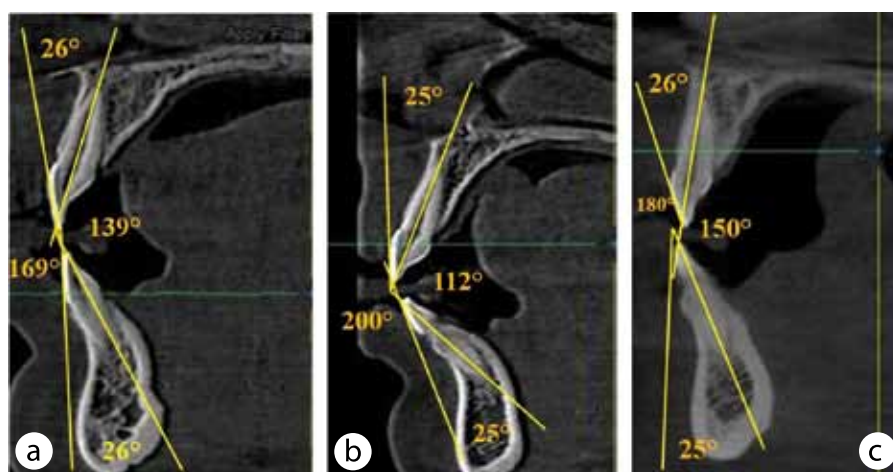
Cone-beam computed tomography images of patients with mesotrusion (a), protrusion (b) and retrusion (c) of central incisors
